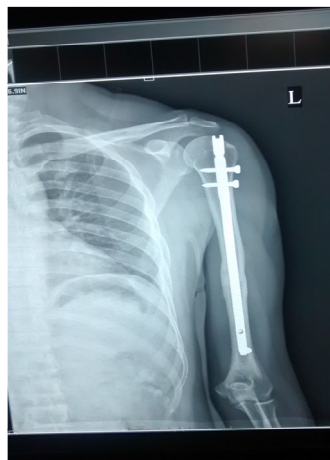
Follow up X-ray
